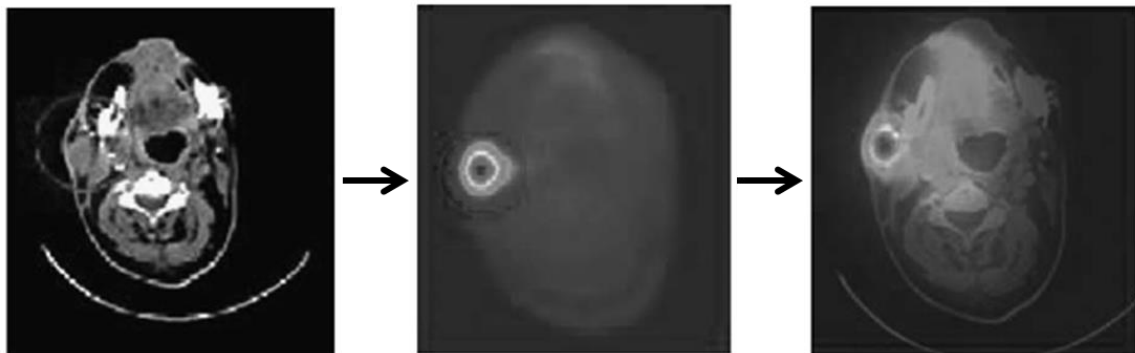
Dose kernel convolution using both anatomical and functional image information to produce a dose map. The CT image on the left provides tissue density information. The center image represents the distribution of activity which is convolved with the dose kernel. The image on the right is the resulting dose distribution (Tsougos et al. 2010).
